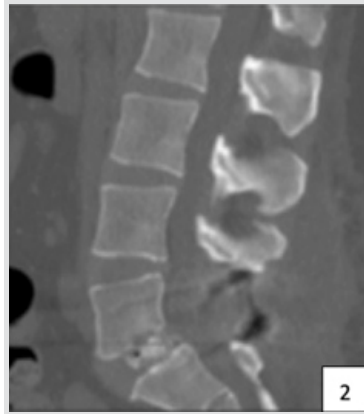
Post-operative computed tomography showing resorption of L5 inferior end plate.
